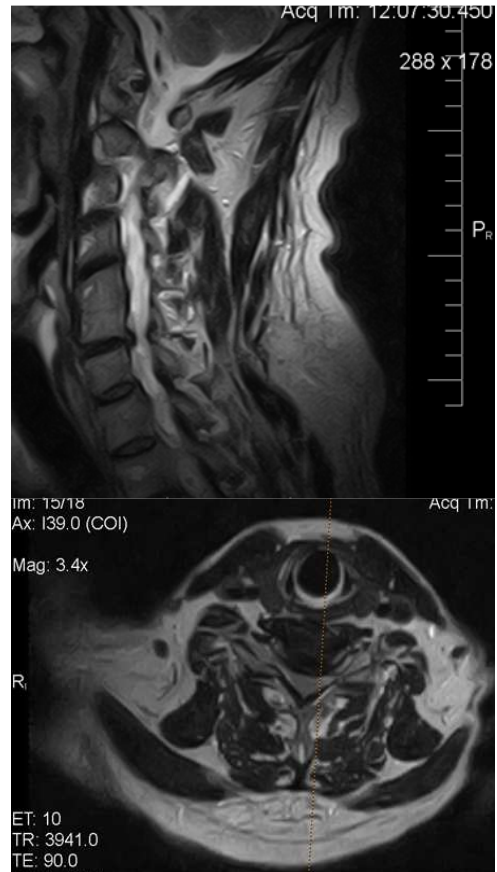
MRI scan: Left C6 – C7 herniated disc
